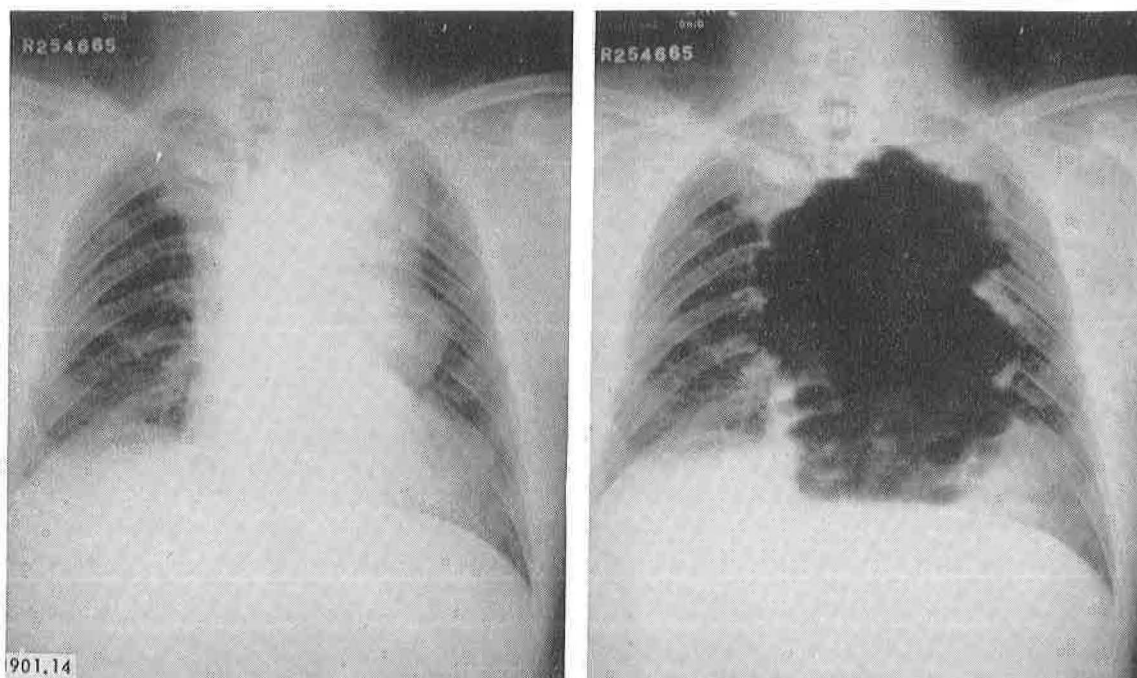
A scan of the blood pools in the heart and aorta performed by the oscilloscopic method is superimposed upon a roentgenogram of the chest. The large mediastinal mass is obviously filled with blood and indicates a large aneurysm of the aorta
